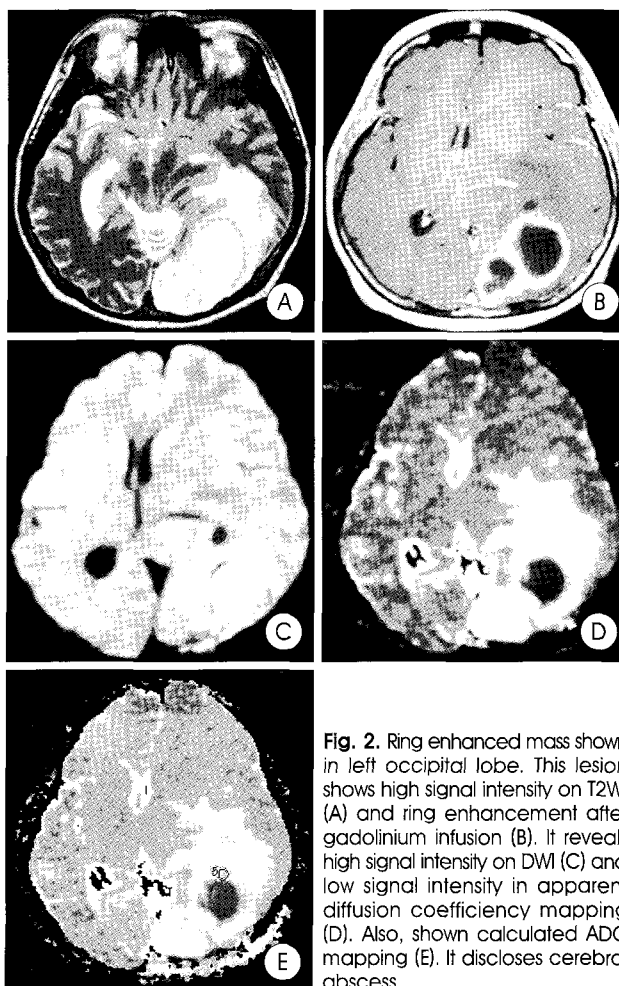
Ring enhanced mass shown in left occipital lobe. This lesion shows high signal intensity on T2WI (A) and ring enhancement after gadolinium infusion (B). It reveals high signal intensity on DWI (C) and low signal intensity in apparent diffusion coefficient mapping (D). Also, shown calculated ADC mapping (E). It discloses cerebral abscess.
